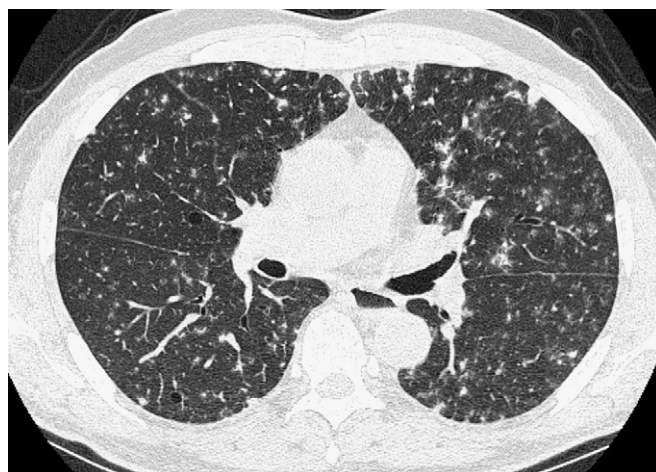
High-resolution computed tomography at the level of the main pulmonary artery, showing multiple ill-defined pulmonary nodules. Two thin-walled cysts are seen in the right lung.
